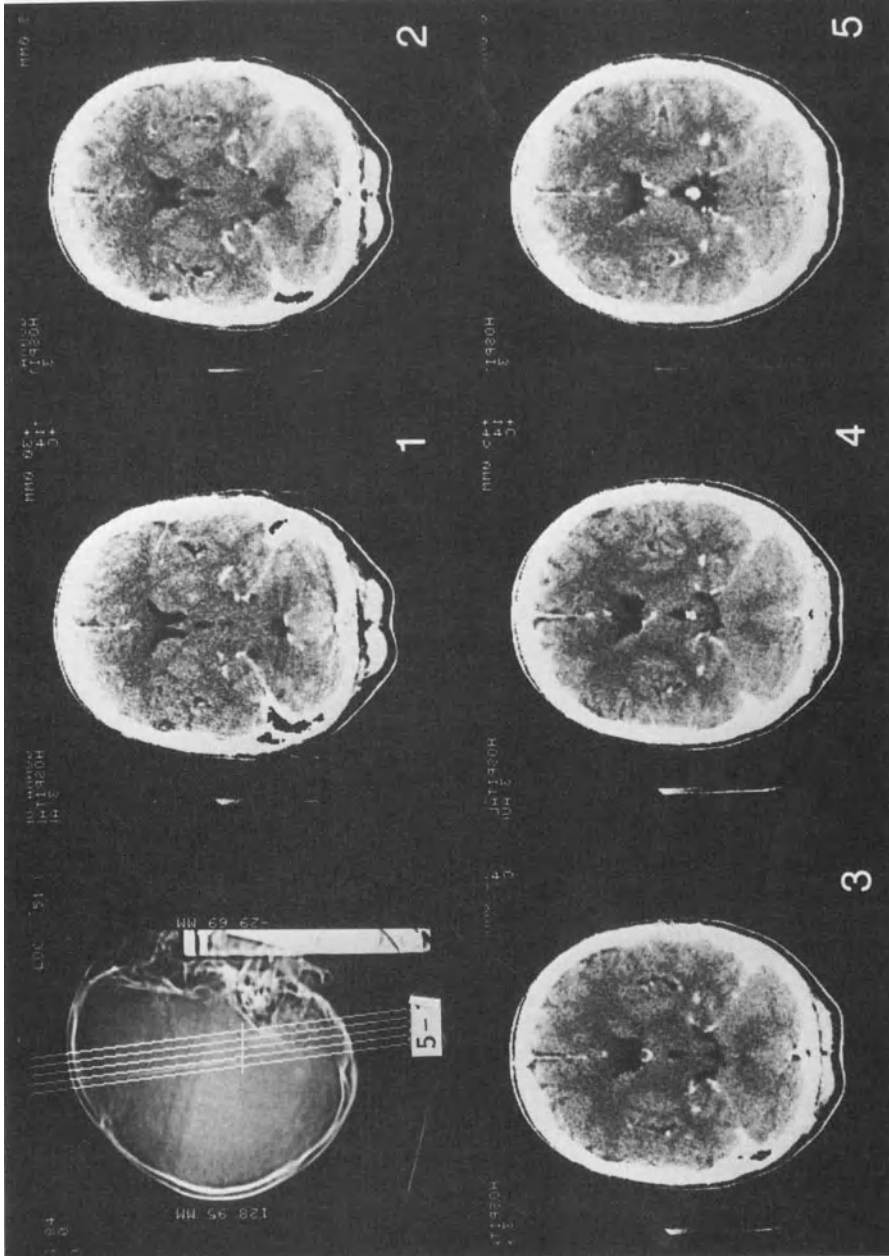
Five stereotactic CT images (1-5) for the direct aid of the stereotactic thalamotomy. Each image clearly shows gray and white matter, especially the caudate nucleus and thalamus. Referring to the foramen of Monro (in image 2) and the cerebral aqueduct (in image 3), image 3 was chosen as a guide plane in this case. (See also figure 24-4.) The five parallel lines in the left "scout" view correspond to the level (5-1) of each image. The angle and the tentative target point are arrived at by a craniometric method.
